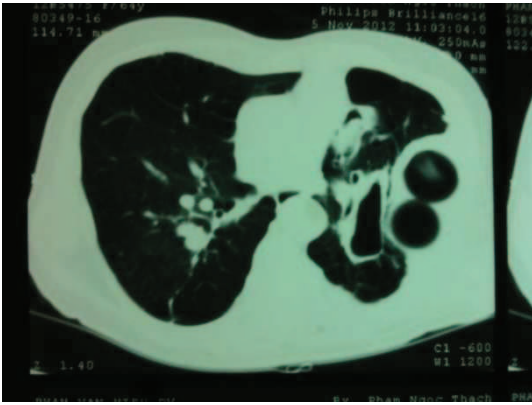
CT Scan at 6 weeks with collapsed cavity.
